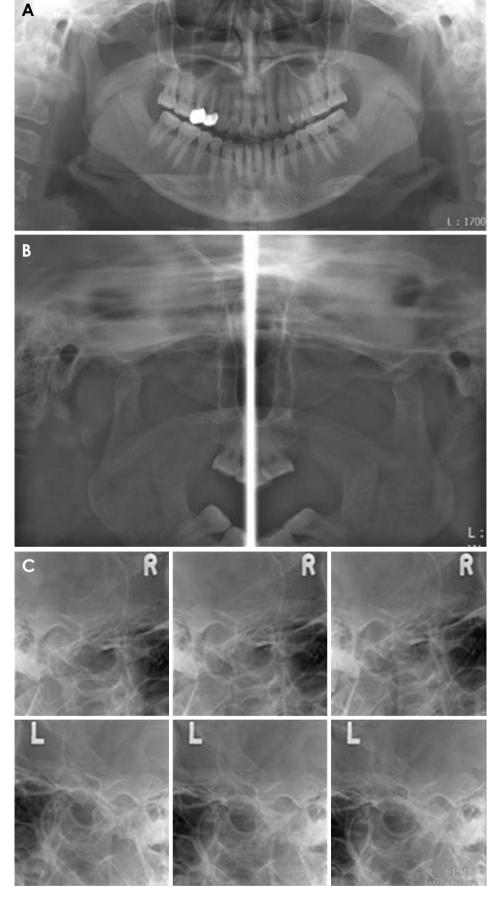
Panoramic (A), temporomandibular joint panoramic (B), and transcranial (C) radiographs taken at the initial visit show no evidence of pathologic bony changes.
